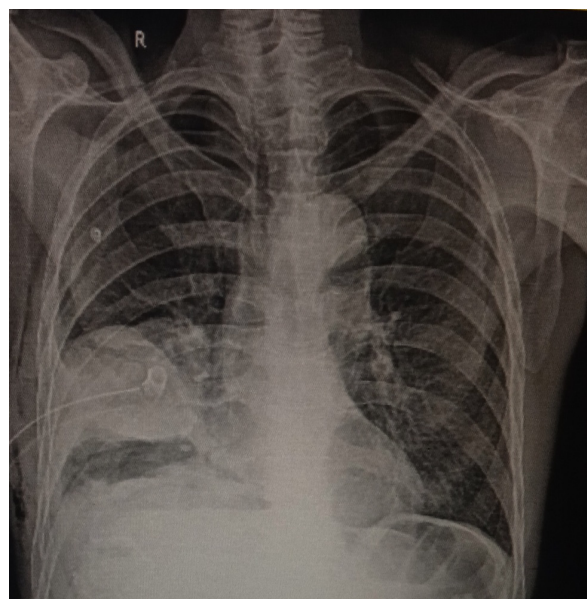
The preoperative chest X-ray showed right lower lobe infiltration and right pleural effusion.
